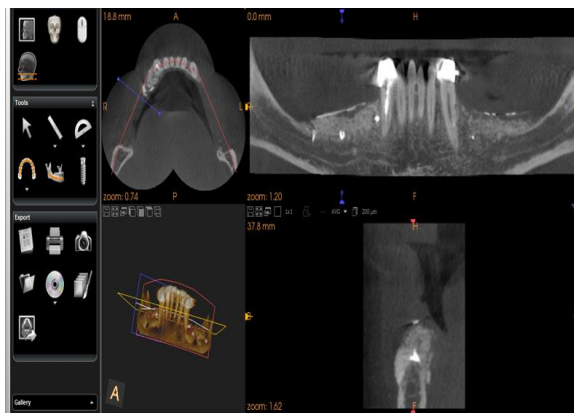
Immediate postoperative CBCT (baseline)
